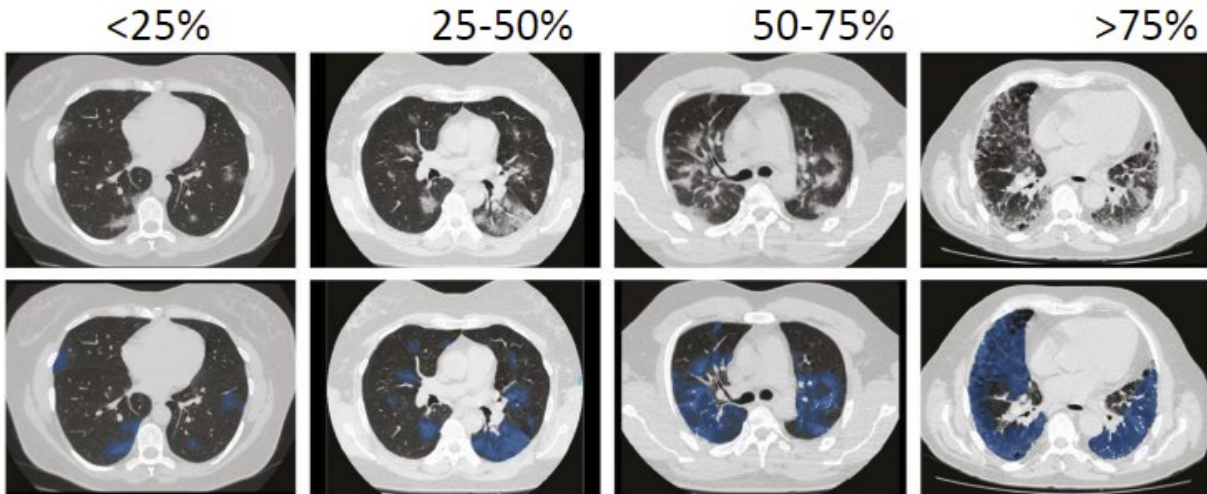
Examples of chest CT scans of patients with varying degrees of COVID-19 severity from the MosMedData. Left to right: mild to critical severity based on percentage of lung affected. Lower row shows the physician annotations added in blue color. [139]
